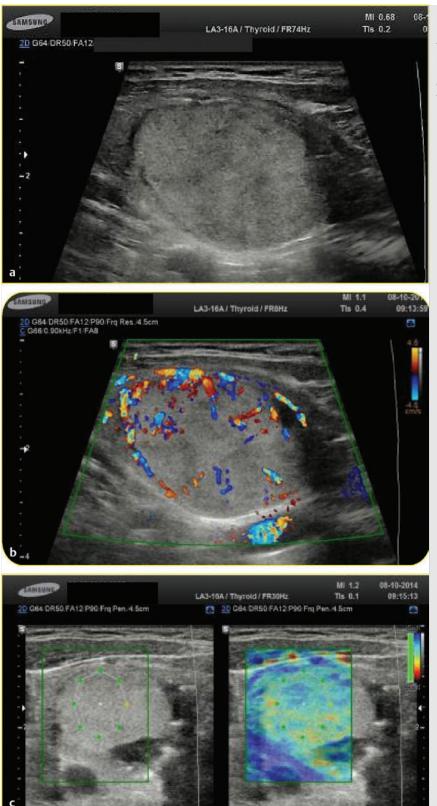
Follicular adenoma. (a) At baseline ultrasound, the lesion appears isoechoic with a tiny halo. (b) At color Doppler, the nodule shows peri-intraleisonal vascularization corresponding to Pattern III. (c) Elasticity contrast index (ECI) evaluation at Elastoscan was lower than 3 and thus consistent with benignity of the lesion.
